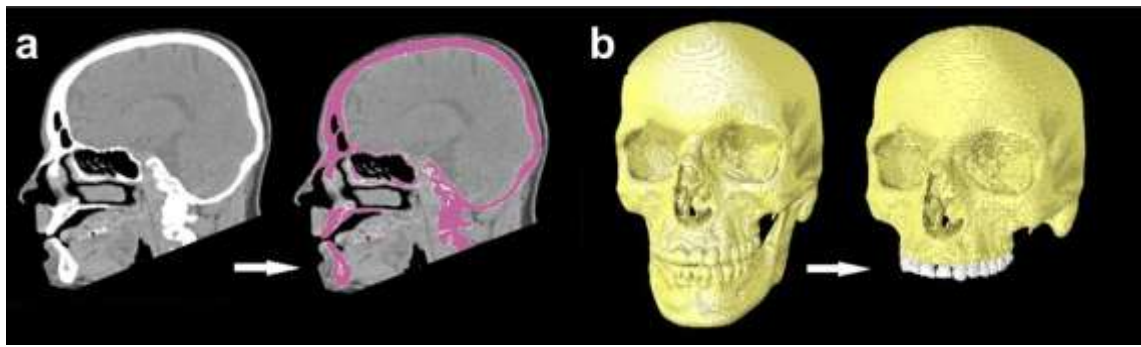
Three-dimensional reconstruction of a human cranium from CT image data. (a) Grey level-based segmentation of the hard tissues (in purple). A (b) volume data of all the hard tissues in the head is generated. With further processing, the maxillary teeth and the mandible have been labelled separately, and the mandible deleted from the final volume data in order to create the model of a cranium.
